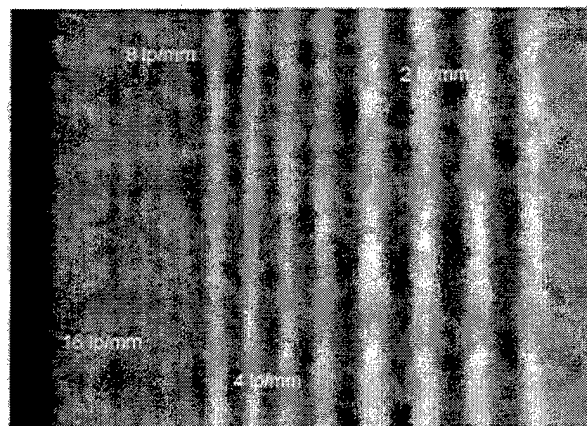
High resolution CT image of line pair gauge
